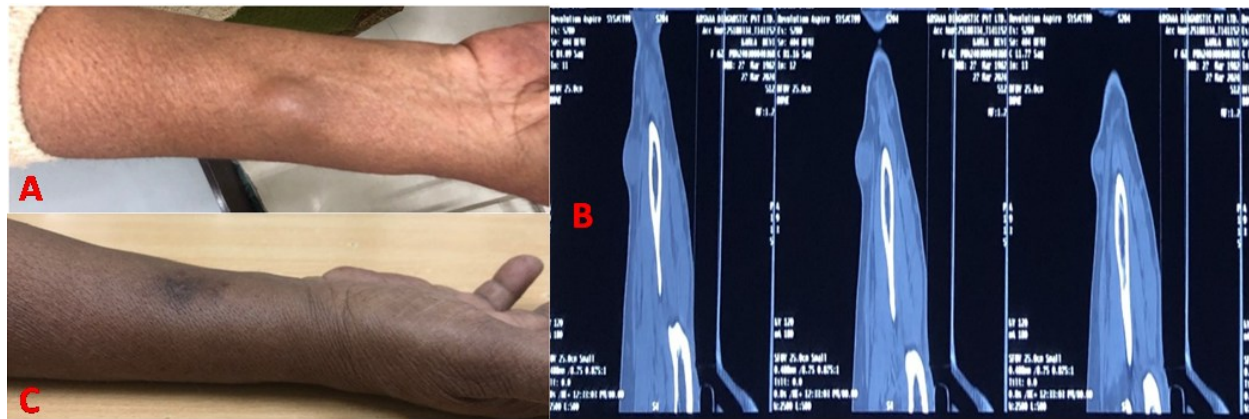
A and C. Pre-operative and post-operative clinical photograph of the patient. B. Non-contrast computed tomography shows a hypodense lesion over the subcutaneous plane of the distal right forearm.
